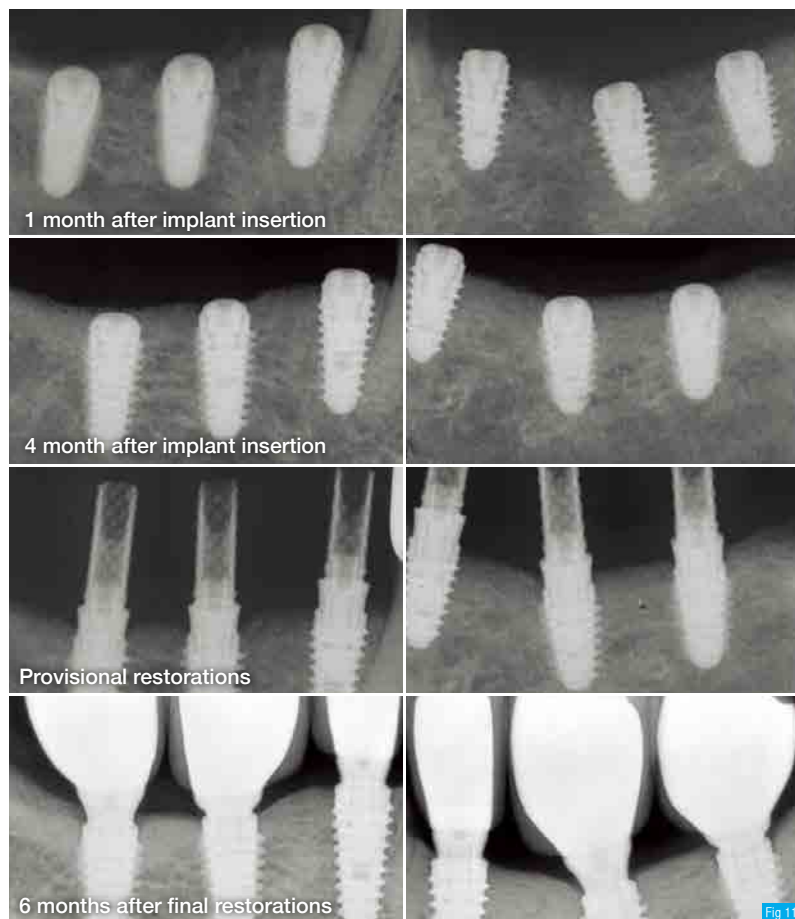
Intra-oral radiographs with clinical procedures and follow-up. All the implants were restored as a single crown. The crestal bone showed excellent response to all implants.
